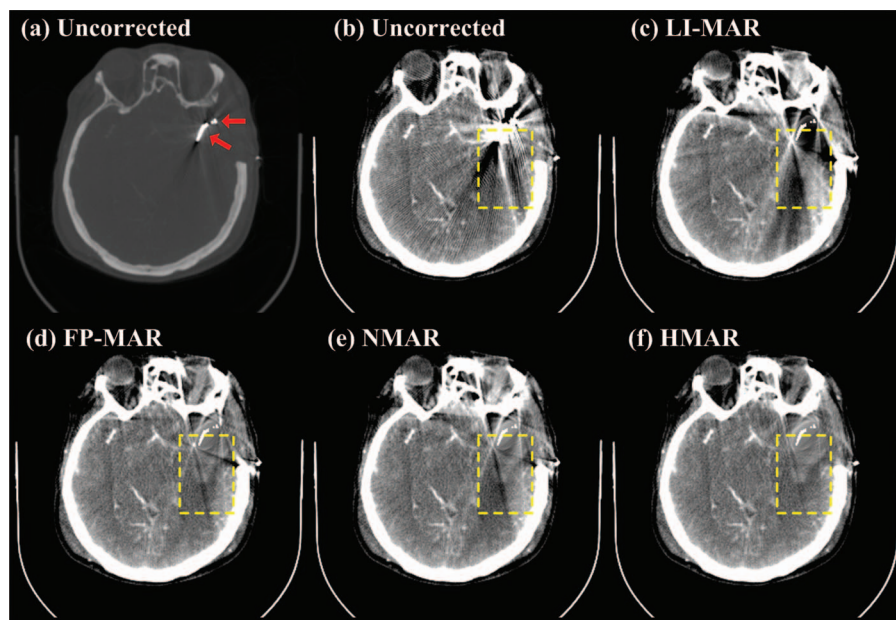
The head CT images show patient 2 with a cerebral artery aneurysm after clipping surgery. (a) and (b) are the uncorrected images, the arrows in (a) point out the clip, and (c)–(f) the corrected results by LI-MAR, FP-MAR, NMAR, and HMAR, respectively. The window width and window level are ($WW = 4000$ HU, $WL = 1000$ HU) for (a) and ($WW = 200$ HU, $WL = 50$ HU) for (b)–(f), respectively.
